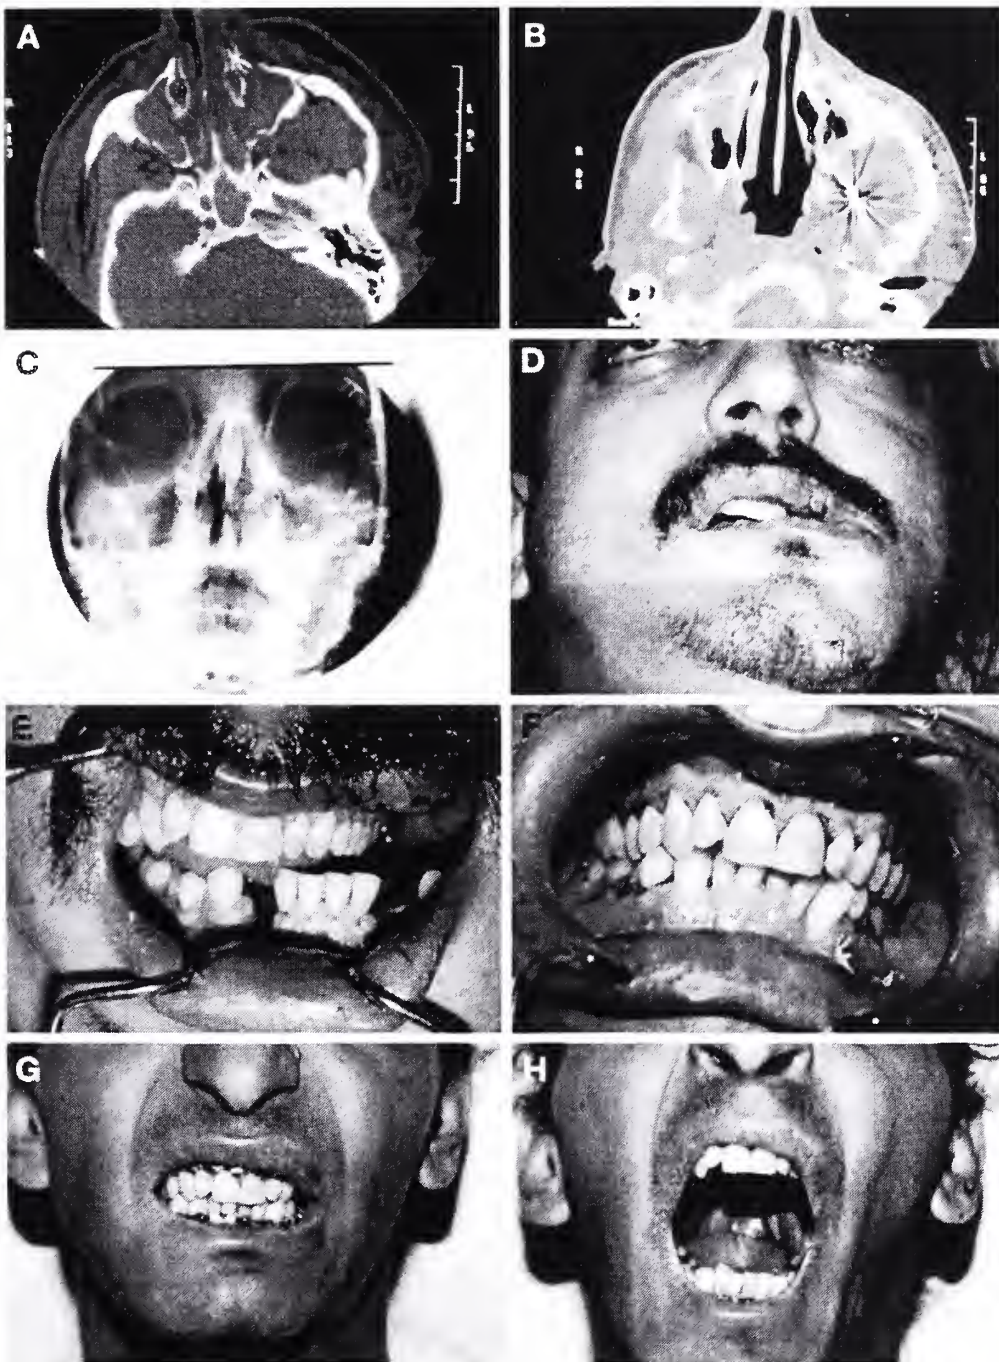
(A) Complex panfacial fracture with left-sided Le Fort III component to the fracture is present on CT imaging. (B) Endoscopic reduction and rigid internal stabilization forms the foundation on which to build the facial reconstruction. (C) Stability of the left facial reconstruction relies on the rigid endoscopically repaired arch. (D) Preoperative midfacial instability is present. (E) Malocclusion results from both midfacial and mandibular injuries. (F) Accurate midfacial repair is essential, in that it becomes the template by which the mandible is restored. (G and H) Four weeks after surgery, the patient had a stable occlusion and excellent jaw function.
